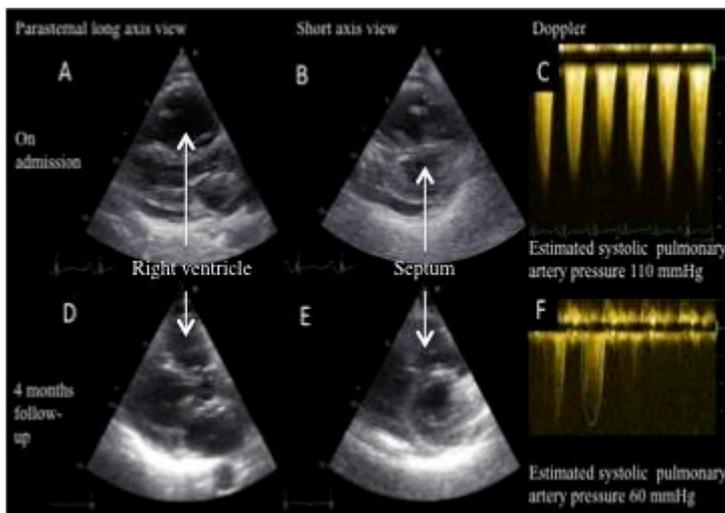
Echocardiography images showing a (A) markedly dilated right ventricle with (B) paradoxical septal motion and (C) elevated systolic pulmonary artery pressure after treatment with dasatinib with improvements on follow-up four months later (panels D, E and F).
